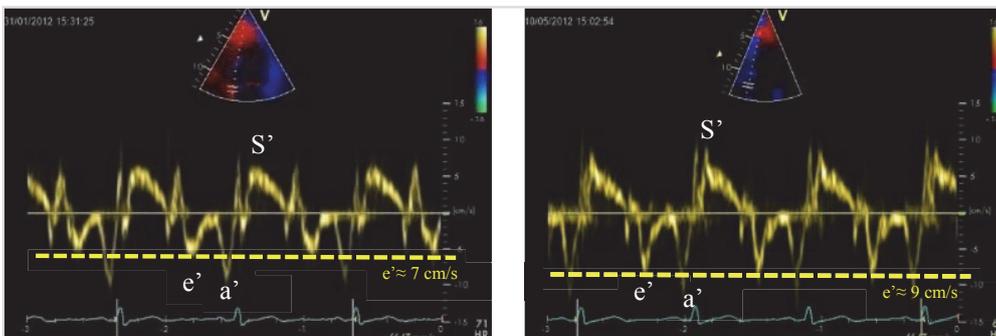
Echocardiographic image from baseline (left panel) and 12-week post-test (right panel) measurement of one of the participants of the present study. Abbreviations: S' , peak systolic tissue Doppler velocity; e' , peak early diastolic tissue Doppler velocity; a' , peak late diastolic tissue Doppler velocity.
